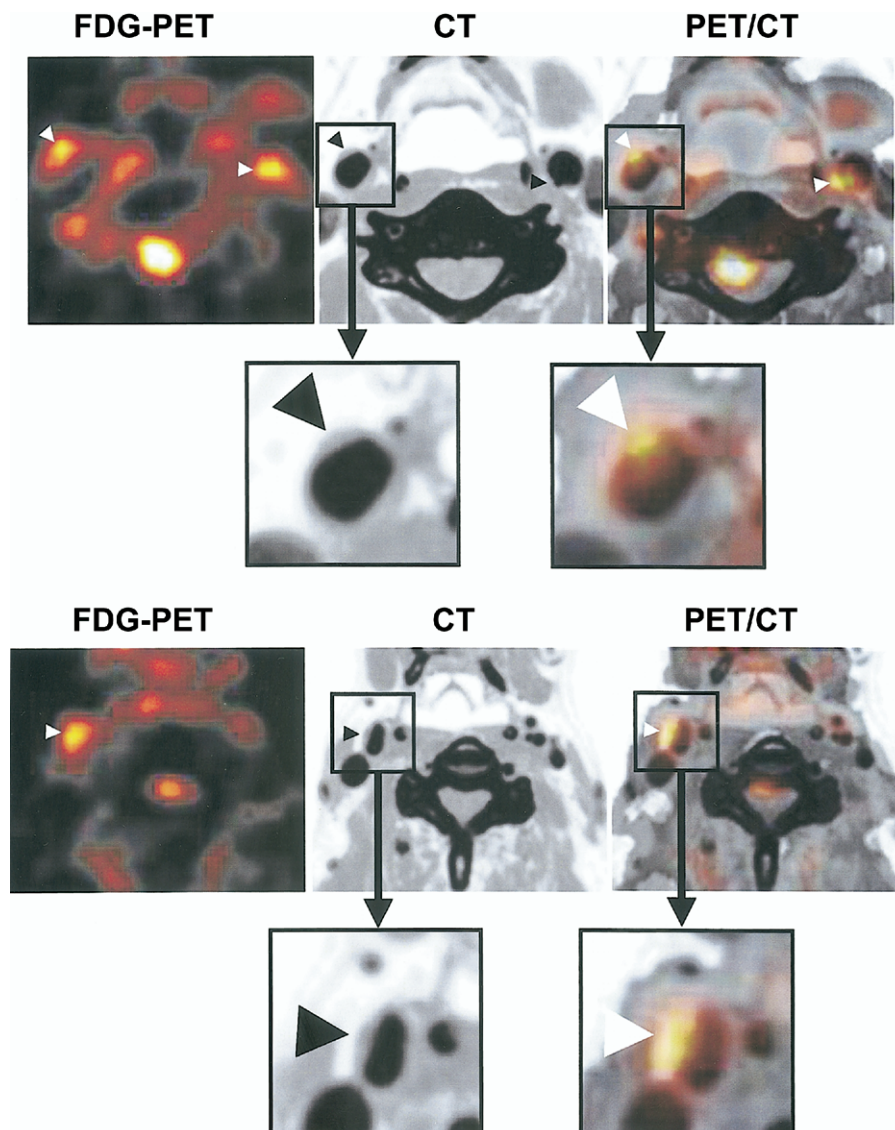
Representative transaxial images of ^{18}F -fluorodeoxyglucose positron emission tomography (FDG-PET) (left), enhanced computerized tomography (CT) (middle), and co-registration of PET and CT (PET/CT) (right) showing ^{18}F FDG uptakes in the carotid arterial plaques (arrowheads) of 2 patients.
